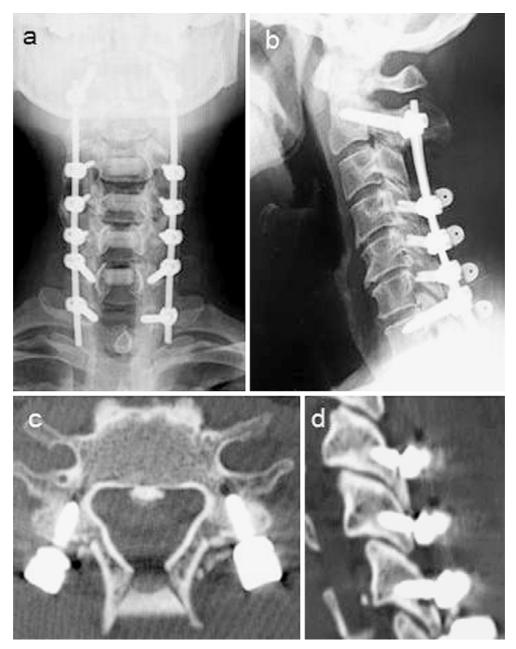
Short monocortical screws (SMS) at C4-C6 as mid-cervical anchor in cervical laminoplasty and instrumented fusion. a Anteroposterior radiograph of cervical spine. b Lateral radiograph of cervical spine. c Axial computed tomographic (CT) view of SMS. d Sagittal CT image of SMS.
